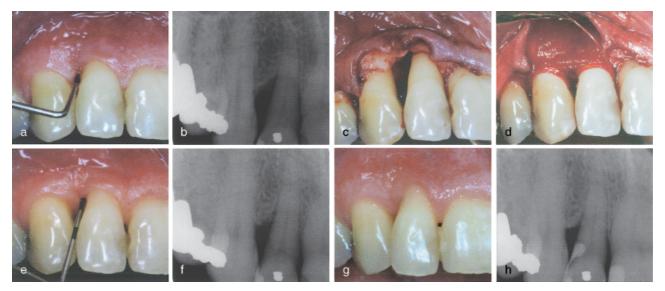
Clinical photograph (a) and radiograph (b) at baseline, of a two-wall defect. After debridement (c), the defect is covered with an absorbable membrane (d). Clinical photographs and radiographs of the treated site after 1 year (e, f), and after 6 years (g, h).
